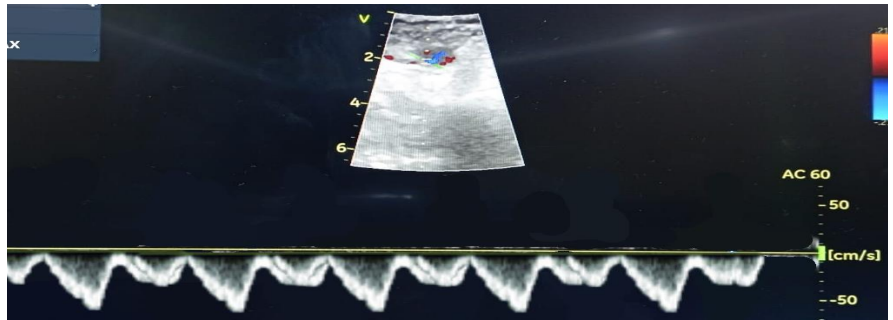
PW Doppler assessment of CFV waves in short axis view showing a mildly congested vein with a pulsatile pattern with systolic and diastolic waves (CFW = common femoral vein).
